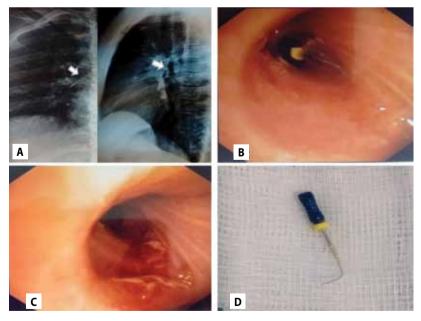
Chest X-ray. Presence of a radiopaque foreign body at the level of the right main bronchus (arrows) (A). Bronchoscopic image of the impacted file in the right main bronchus (B), and after the removal (C). The extracted dental file of ~3cm length (D).
